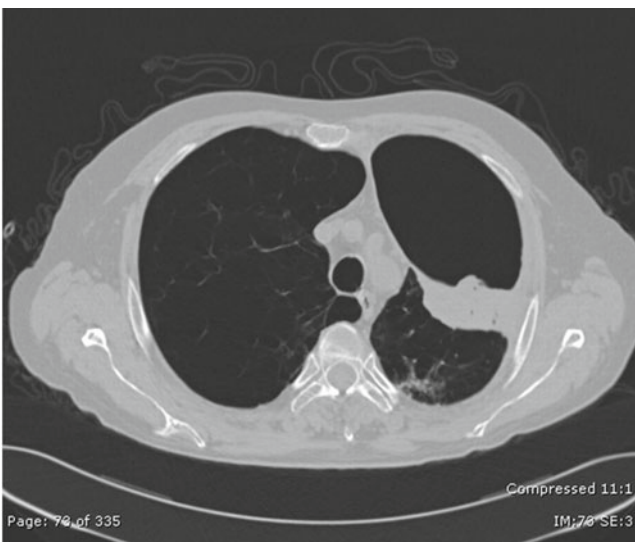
CT from the same patient
